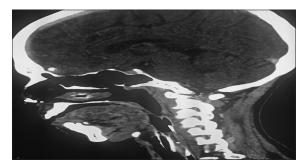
Computed tomography scan imaging of brain showing partial contrast filling defect in frontal Portion of Superior sagittal sinus
